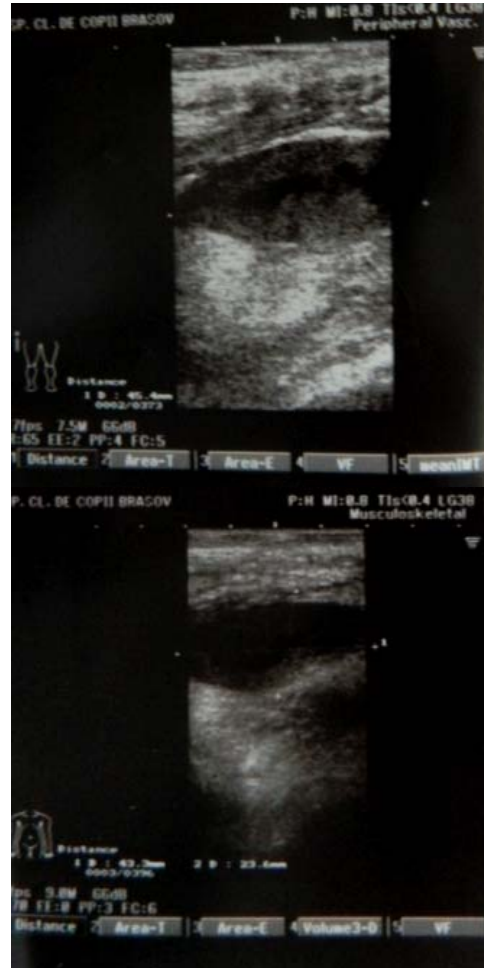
Abdominal ultrasonography showing a collection in the right lower quadrant*
